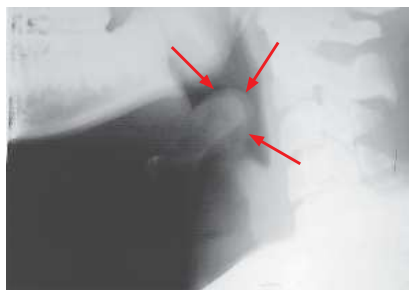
Epiglottitis. Lateral x-ray of the neck shows a markedly swollen epiglottis (arrows) demonstrating the classic “thumbprint sign,” with near-complete airway obstruction. (Reproduced with permission from Stone CK, Humphries RL. *Current Diagnosis & Treatment: Emergency Medicine*, 6th ed. New York, NY: McGraw-Hill; 2008.)
